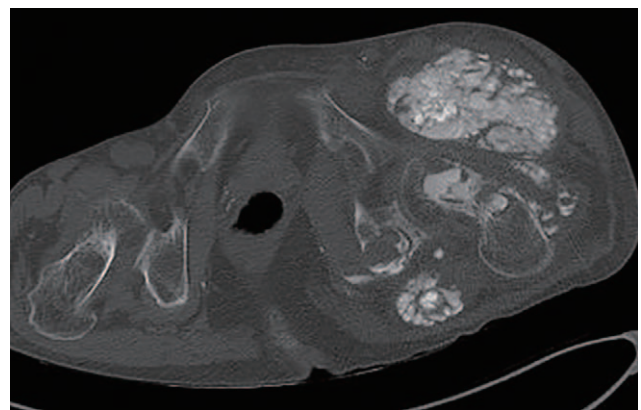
Preoperative axial view of the pelvic computed tomography. It showed intramedullary invasion of the tumoral calcinosis accompanied by pathologic fractures of the femoral neck.
